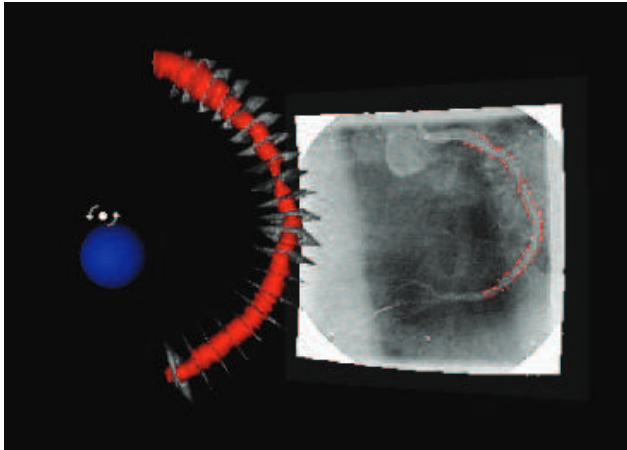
3-D geometrically correct reconstruction of human coronary artery imaged in vivo using biplane X-ray angiography and intravascular ultrasound (IVUS). Note the X-ray projection image with coronary boundaries segmented and a subset of IVUS images fused with the 3-D reconstructed coronary artery.
